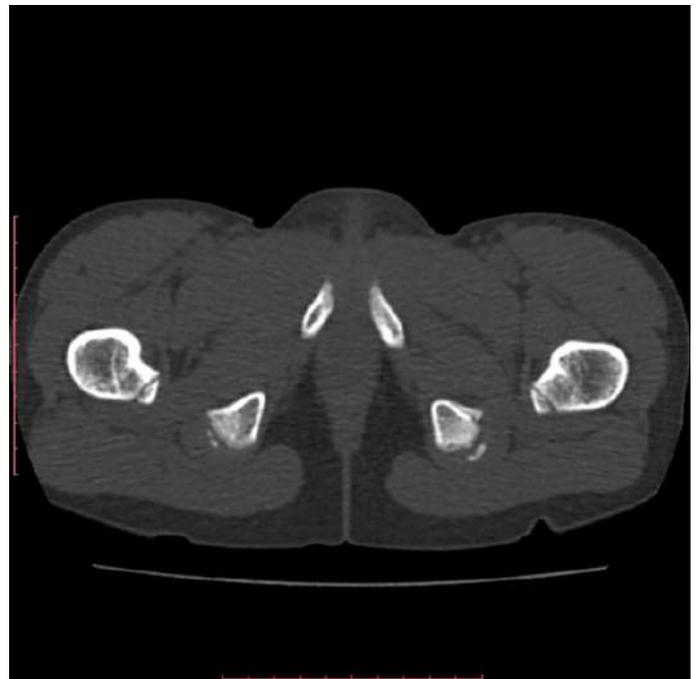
Pelvic CT scan. Axial slice, bony window. Well-defined bony lesions with distinct margins are present in the area of the ischial tuberosities. The ischial bones have fuzzy contours posteriorly. The depicted lesions are apophyses with developing ossification centers.
